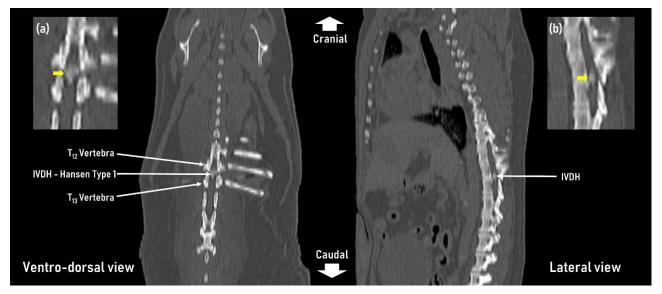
Lateral radiograph of thoraco-lumbar spine. Reduced intervertebral space between  $T_{12}$  and  $T_{13}$  thoracic vertebrae (yellow arrows)
